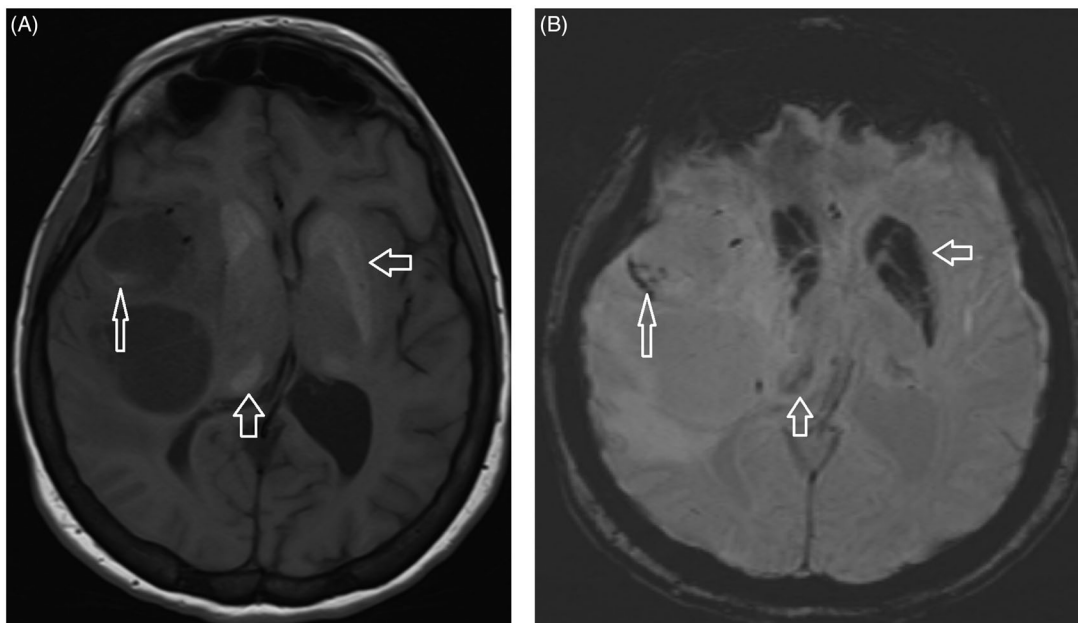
Signal change indicating basal ganglia calcification (thick arrows) and anteriorly located cyst calcification (thin arrows) was observed on (A) T1-weighted imaging and (B) susceptibility weighted imaging (SWI).
